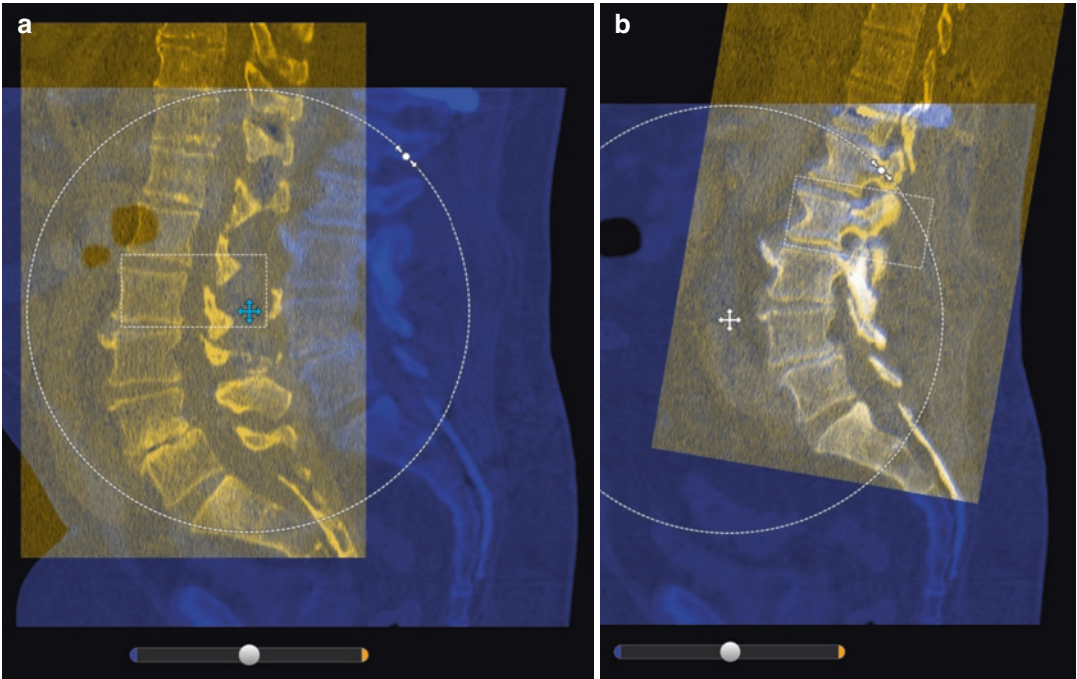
Screen view of elastic image fusion of the pre-operative CT (yellow) and the intraoperative CT (blue) of a lumbar spine. The level to be operated on (L4/L5) is matched on both scans manually before the digital image
